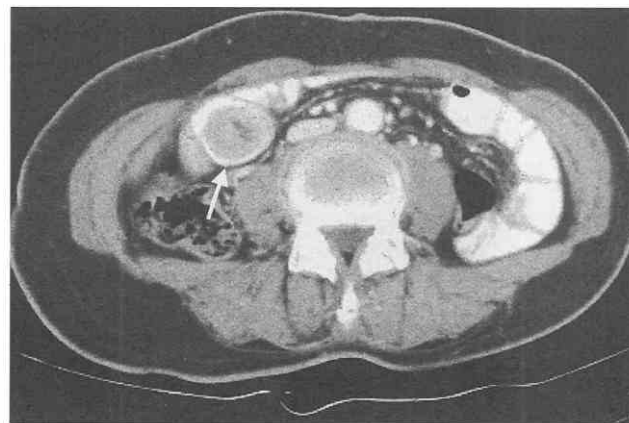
Transient jejunojejunal intussusception after gastrectomy. CT scan shows heterogeneous masslike lesion in the jejunal loop caused by invagination of the regional mesentery into the bowel lumen. Small-bowel follow-through study (not shown) did not demonstrate any mass.
